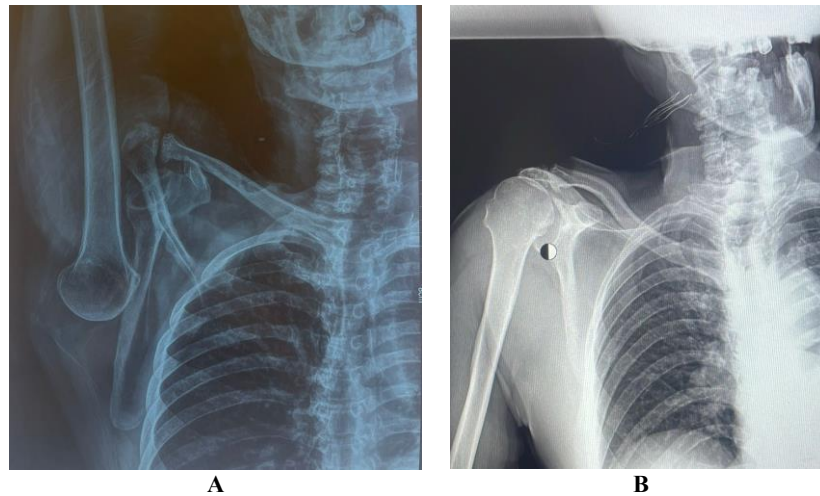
First case. (A) Initial radiograph of the right shoulder showing an inferior glenohumeral dislocation. (B) Post-reduction radiograph showing restoration of glenohumeral congruity.
